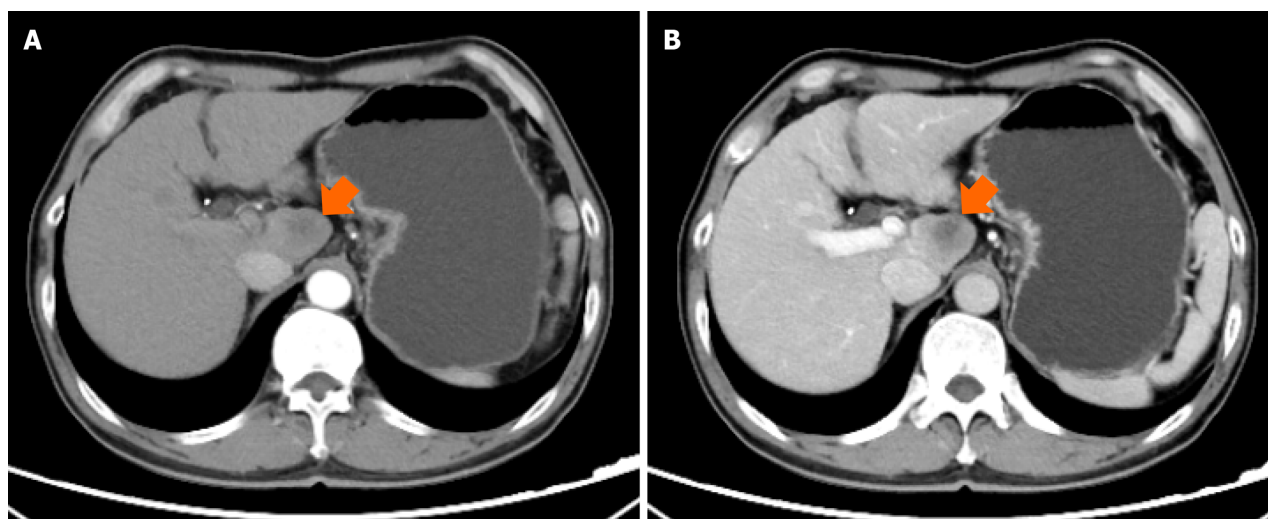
Computed tomography imaging of liver lesion. A: The arterial phase of computed tomography (CT) showed no obvious enhancement (orange arrow); B: The venous phase of CT showed slightly heterogeneous enhancement (orange arrow).
